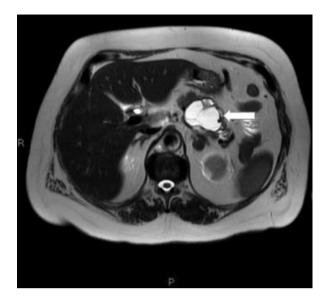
Axial CT scan of a mucinous cystic neoplasm arising from *body of the pancreas* (white arrow)
